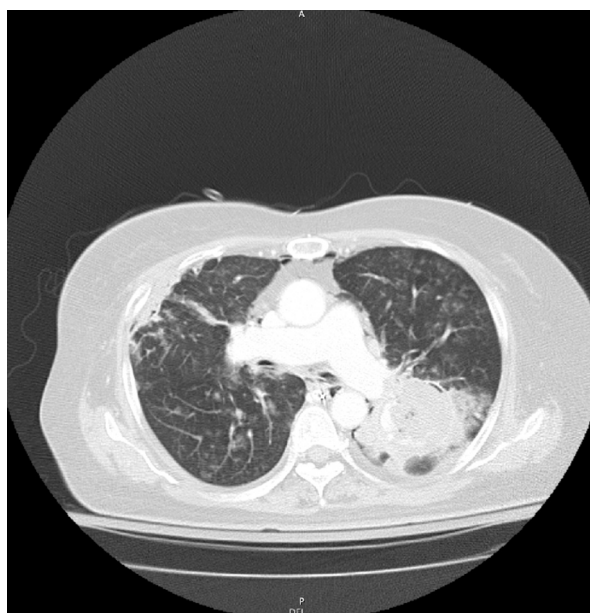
Transverse CT of the chest showing the lung window of a left upper lobe cavitation in direct contact with the left lower branch of the pulmonary artery
